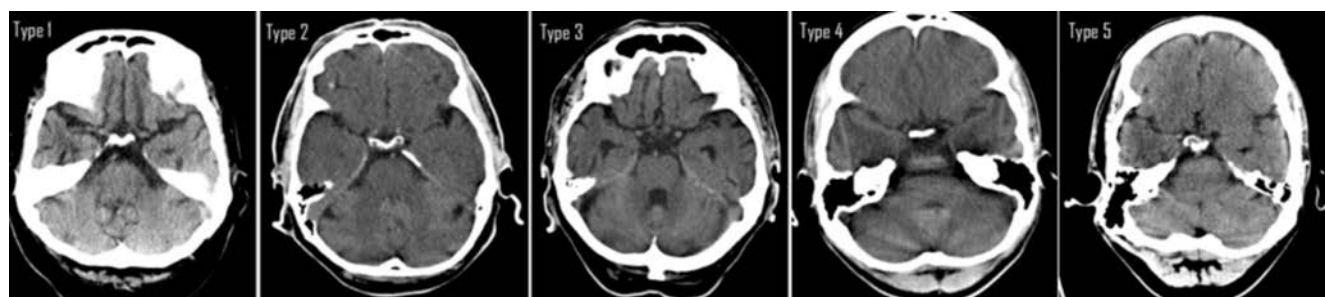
Definition of the Sylvian fissure types on computed tomographic scanning.
